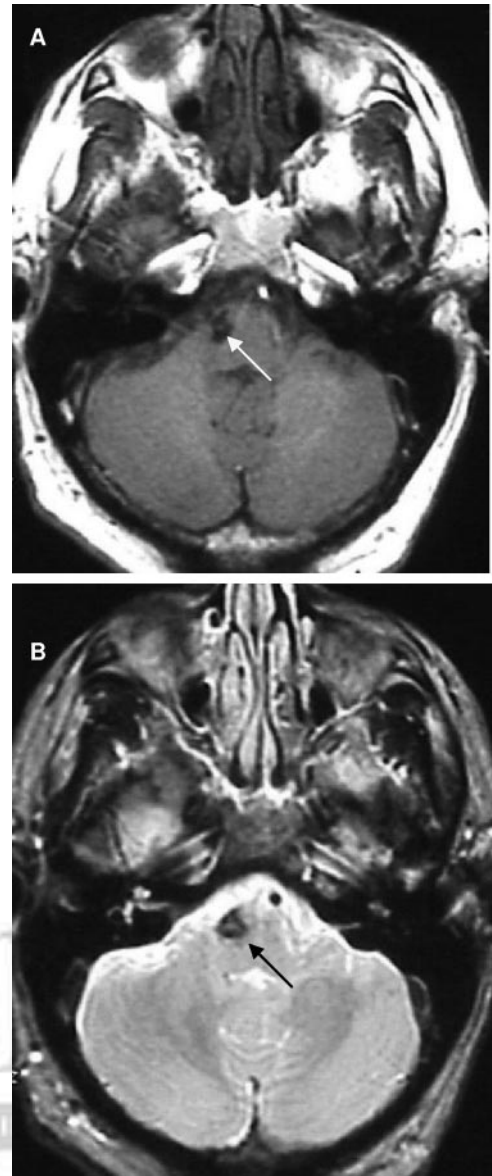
CM nonhemorrhagic focal neurological deficit. This 50-year-old man presented with transient symptoms of right facial numbness, left hemibody numbness and weakness, and vertigo, in the setting of a known right anterolateral pontine CM. Imaging studies included (A) T₁-weighted and (B) T₂-weighted brain MRI, brain CT, and CSF studies (not shown), all failing to confirm any evidence of recent hemorrhage, or change from previous studies. Ultimately, the patient was diagnosed with polycythemia, and the symptoms resolved in conjunction with therapeutic hemodilution.
